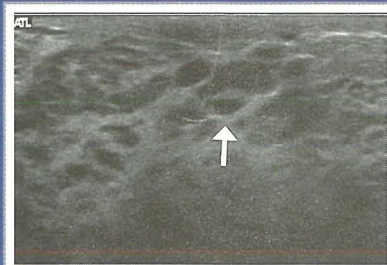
Retroareolar duct ectasia: Ultrasound scan demonstrates dilated anechoic ducts (arrow) seen in cross section deep to the areola.
